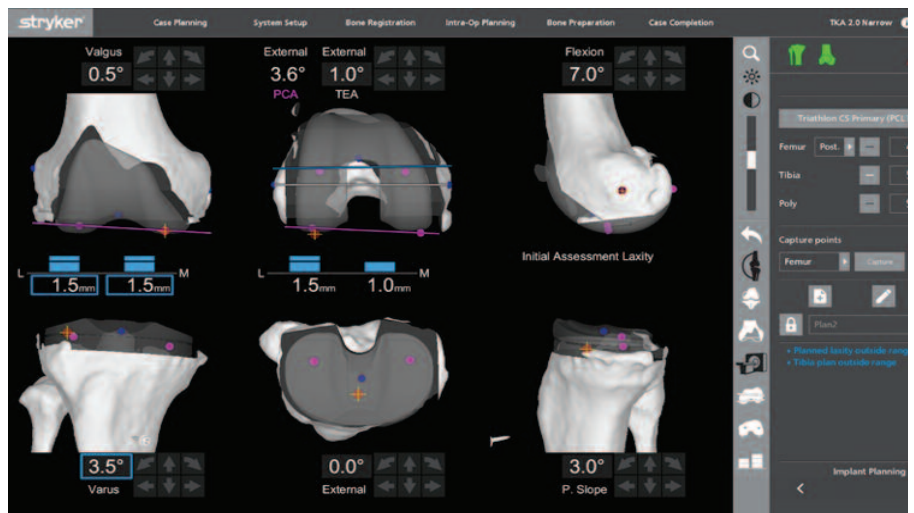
Computed tomography scan screen based upon alignment parameters and landmark registration obtained previously. Including laxity bars for visual and ease of balancing laxities. Also, there is the ability to toggle between implant and resection views.
